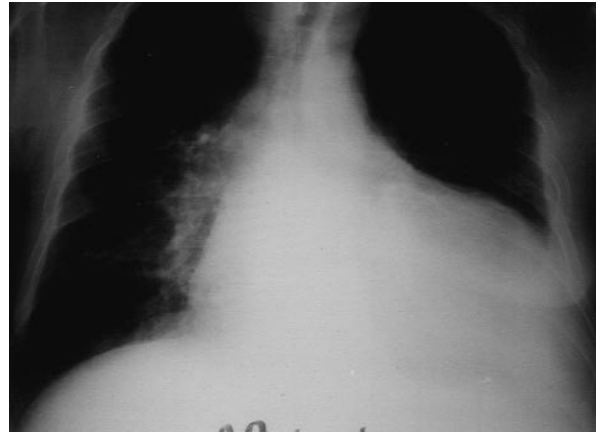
Chest X-ray performed after puncture of the right pleural effusion.
